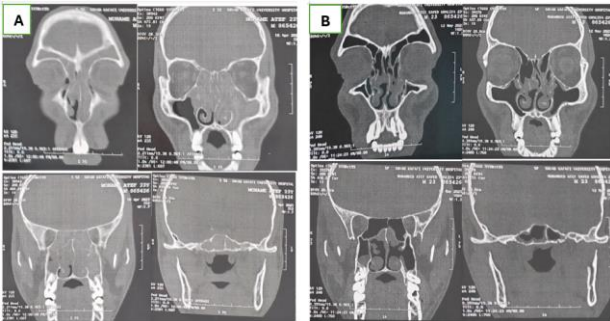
A: CT scan for a case with Lund Mackay score 18 before administration of dupilumab. B: CT scan for the same case with Lund Mackay score 10 after 6 months of administration of dupilumab
